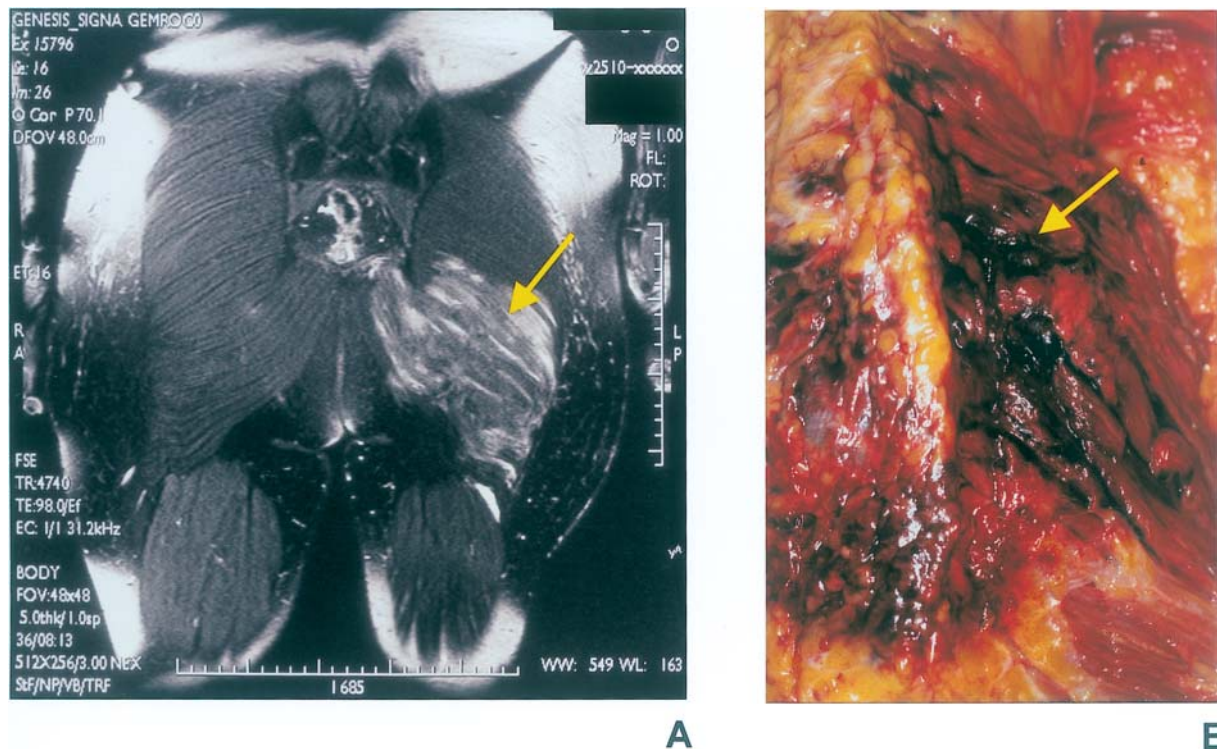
Contusion and hematoma of the right musculus gluteus maximus after a bicycle/motor vehicle accident (Case 018): (a) coronal T2-weighted fast SE MR image (4740/98) showing the signal-intensive contusion zone (arrow); (b) corresponding area during the autopsy (arrow).
